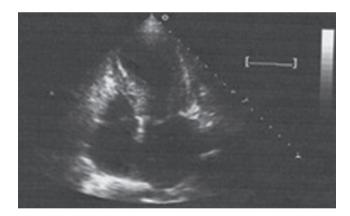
Echocardiography showed improved left ventricular motion subsequent to treatment for 1 week.
